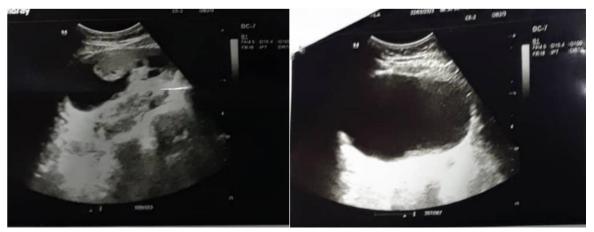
Ultrasound image of the adnexal structures
